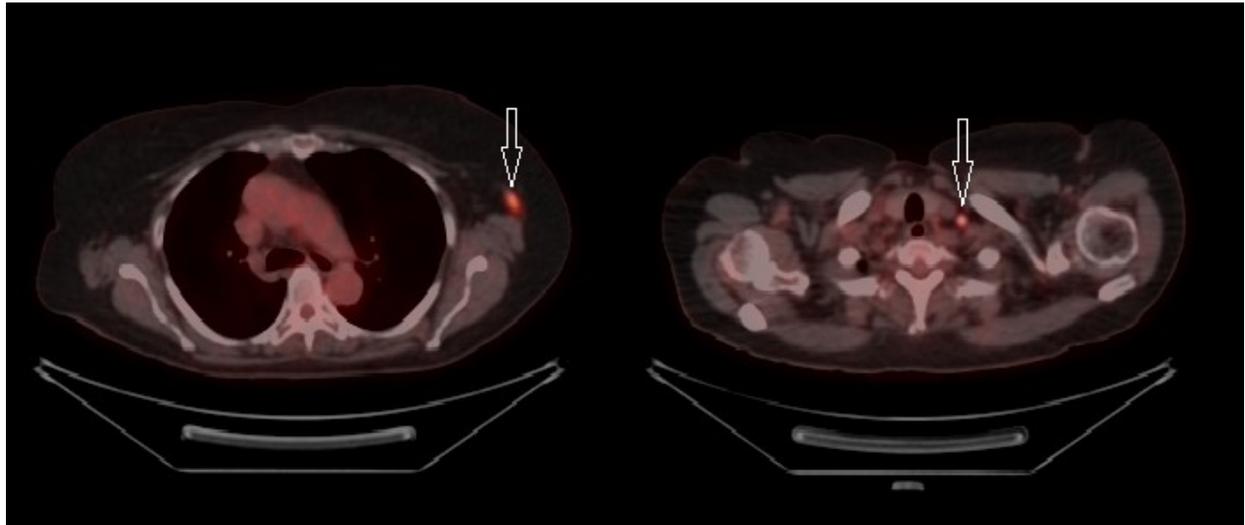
Fluorine-18 fluorodeoxyglucose positron emission tomography associated with computed tomography images revealed an area of increased metabolic activity in the left axillary and left supraclavicular lymph nodes (arrows).
